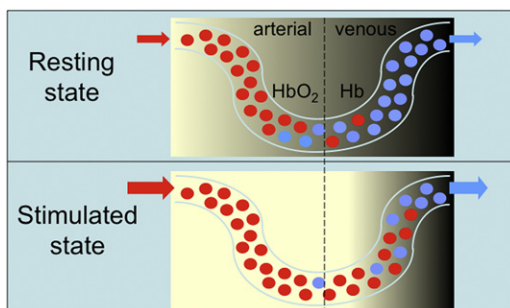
Sketch of brain tissue containing a capillary during rest (*top*) and activation (*bottom*). Red and blue circles represent red blood cells that are fully oxygenated (HbO_2) and fully deoxygenated (Hb), respectively. The MRI signal is depressed in the venous side of the capillary due to the paramagnetic susceptibility of the Hb acting as an endogenous contrast agent (shown darker). In the stimulated condition, increased blood flow causes the Hb to be swept out and replaced by HbO_2 , causing a BOLD signal increase.
